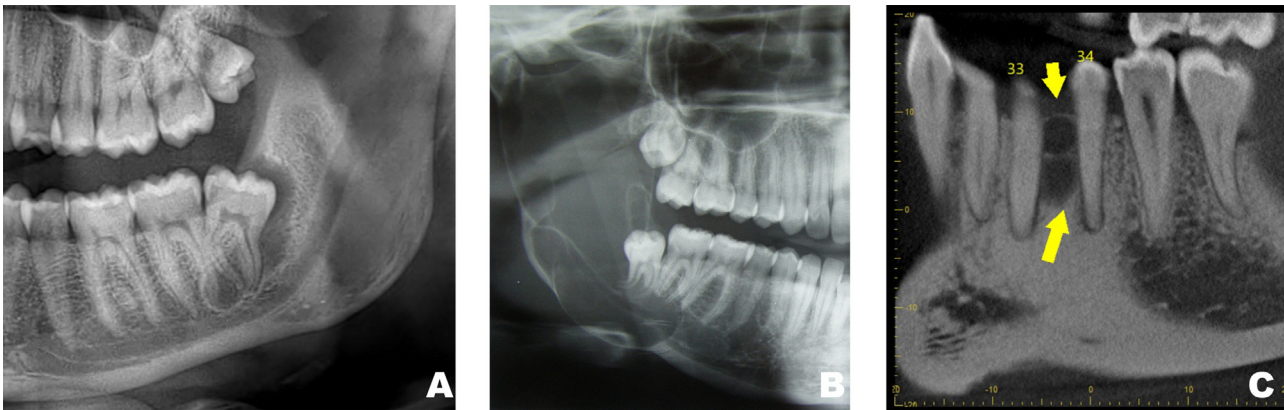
Radiographic features of keratinized odontogenic cysts. (A) Panoramic view showing an unilocular radiolucency surrounding the distal aspect of a partially erupted molar. The final diagnosis was an orthokeratinized odontogenic cyst. (B) Panoramic view showing an extensive multilocular radiolucency involving the right ascending ramus. The final diagnosis was an odontogenic keratocyst. (C) Sagittal section of a CBCT showing a multilocular radiolucency in a “lateral periodontal” emplacement. The final diagnosis was surprisingly a keratocyst.
